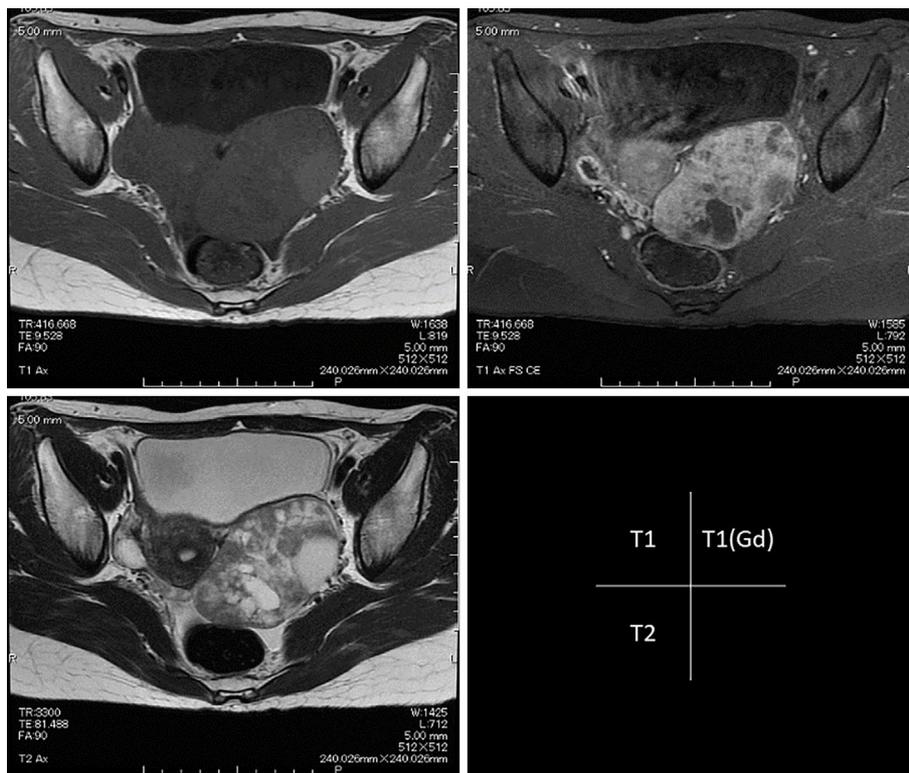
Gadolinium-enhanced magnetic resonance imaging of the ovarian tumor. The left ovarian tumor contains a solid component exhibiting a higher signal than the muscle on T1- and T2-weighted imaging. Gadolinium-enhanced imaging showed an admixture of enhanced solid components and cysts.
